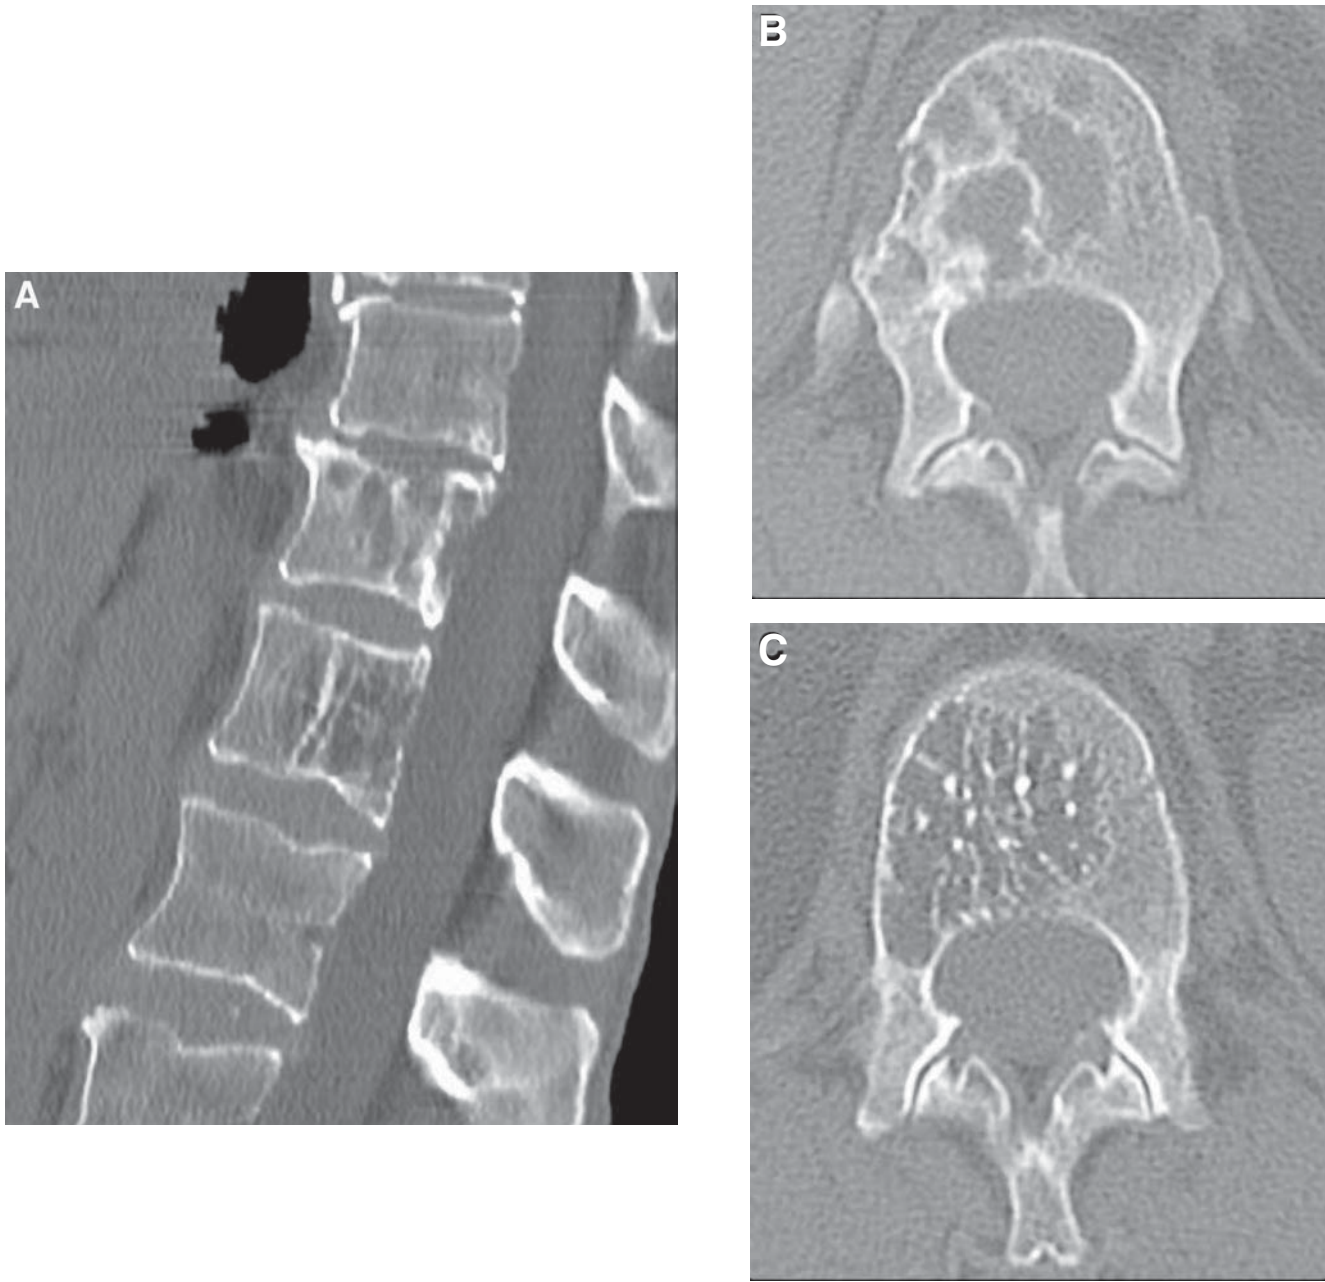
(A) Sagittal CT reformation reveals predominately osteolytic foci involving both the L1 and L2 vertebrae in a patient with suspected metastatic breast carcinoma. (B) Axial CT at the L1 level shows irregular areas of lytic bone destruction with a small break in the cortex laterally. This proved to be metastatic disease. (C) Axial CT at the L2 level demonstrates the classic “corduroy” appearance of a vertebral hemangioma. Note the prominent vertically oriented trabeculae on both the axial and sagittal images.
